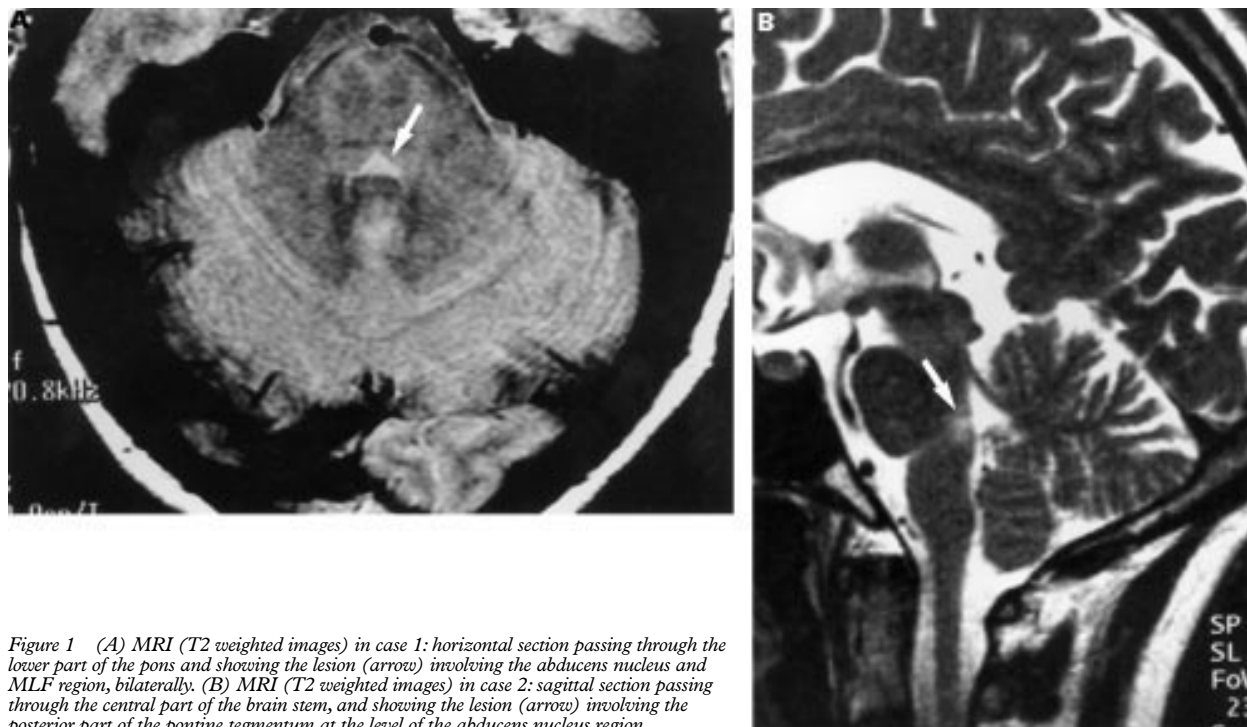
(A) MRI (T2 weighted images) in case 1: horizontal section passing through the lower part of the pons and showing the lesion (arrow) involving the abducens nucleus and MLF region, bilaterally. (B) MRI (T2 weighted images) in case 2: sagittal section passing through the central part of the brain stem, and showing the lesion (arrow) involving the posterior part of the pontine tegmentum at the level of the abducens nucleus region.
